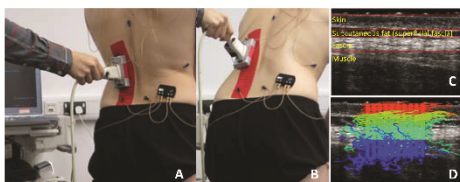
A&B: Ultrasound scanning during movement with standard lower back Kinesio-taping. The ultrasound probe head was attached with a frame and 3 motion markers to reduce swinging artefact. C&D: Demonstration of ultrasound tracking algorithm. Bottom subfigure shows an example of results of 60 tissue movement routes during the lumbar flexion task.
